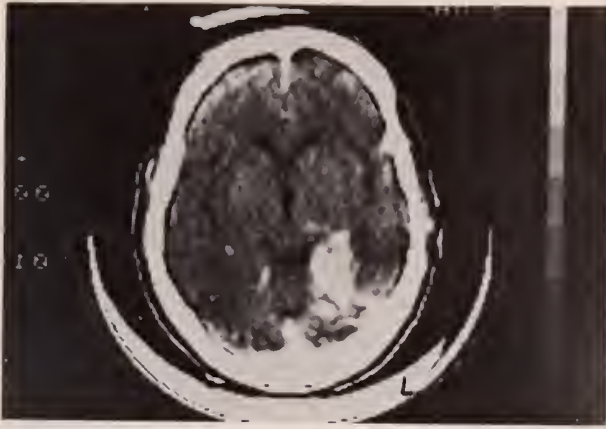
Post contrast CT scan, Case 1.
